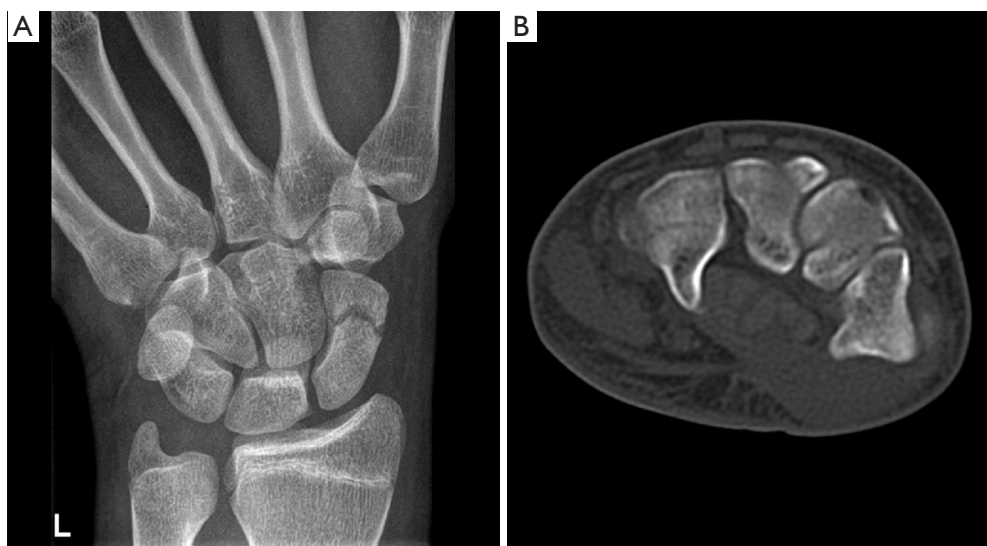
Left side. (A) Front, pronated wrist radiograph, scaphoid and capitate fracture. (B) CT coronal, hamate corpus fracture.
